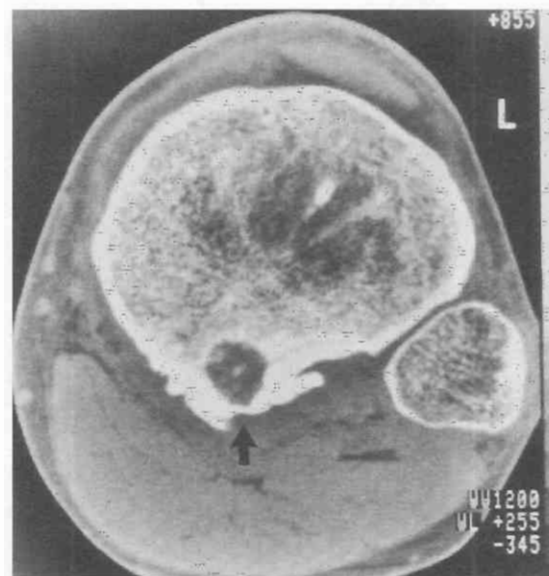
Osteoid osteoma. CT scan of the proximal left leg shows a well-defined nidus with central mineralization and associated periosteal reaction at the posterior aspect of the proximal left tibia (arrow).
